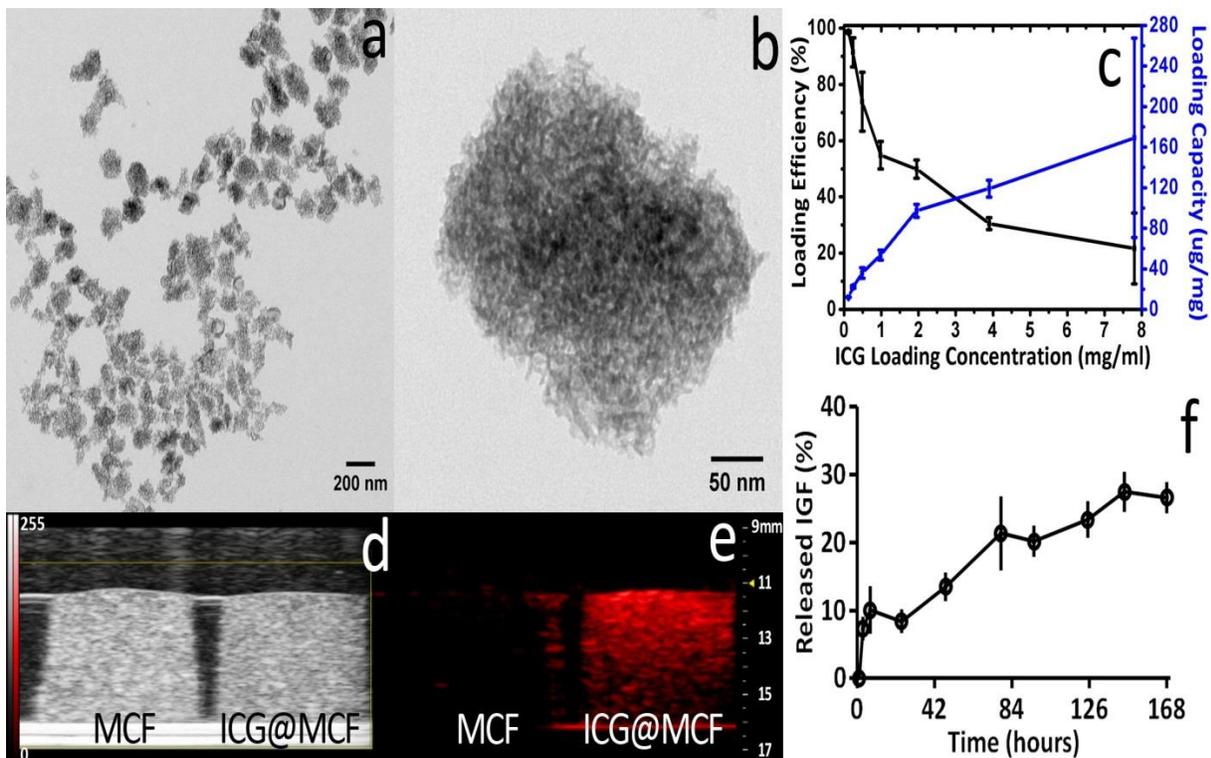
(a, b) TEM images of mesoporous cellular foam (MCF). (c) Loading efficiency and capacity of ICG into MCF. (d) Ultrasound and (e) photoacoustic images of MCF and ICG loaded MCF (ICG@MCF). (f) In vitro release of IGF@MCF in PBS at 37°C.
